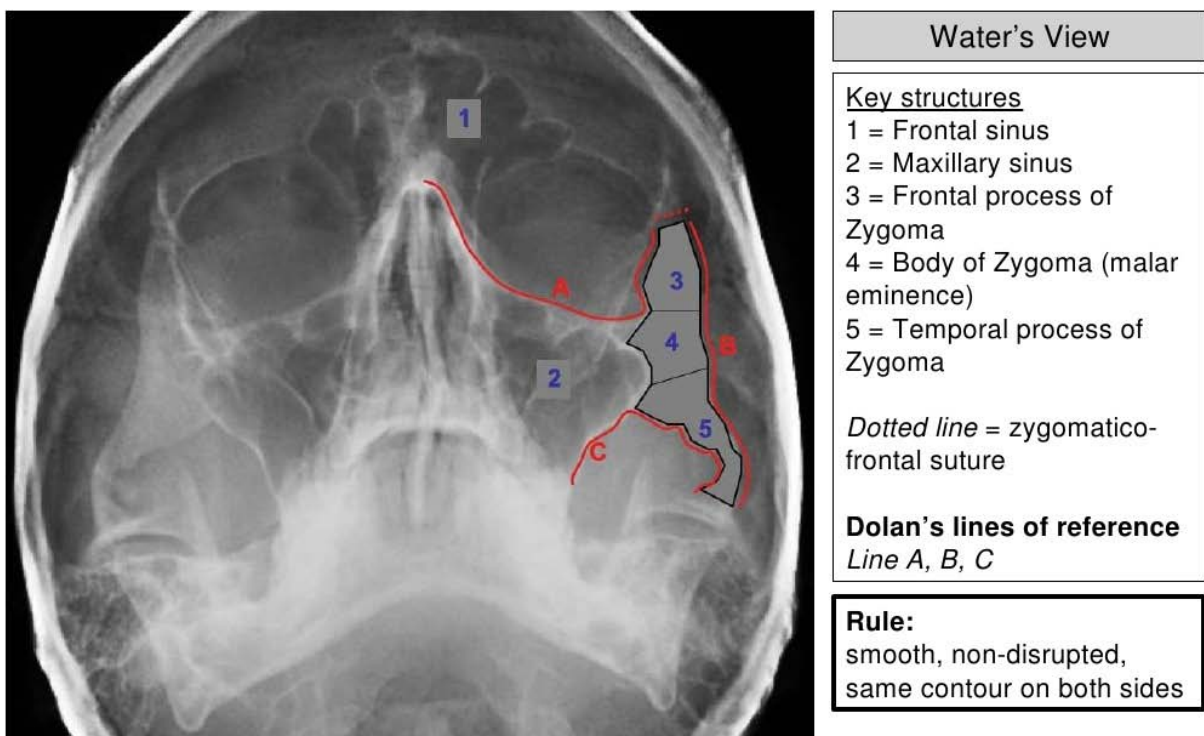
ZMC radiographic markers on Water's view radiograph [5]
